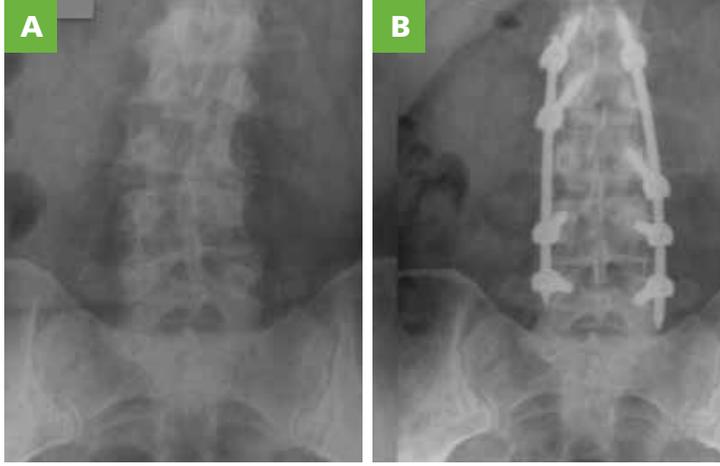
Comparison of A, anteroposterior (AP) preoperative x-ray to B, 2.5-month postoperative x-ray. The mild coronal deformity was corrected and maintained correction at follow-up.
